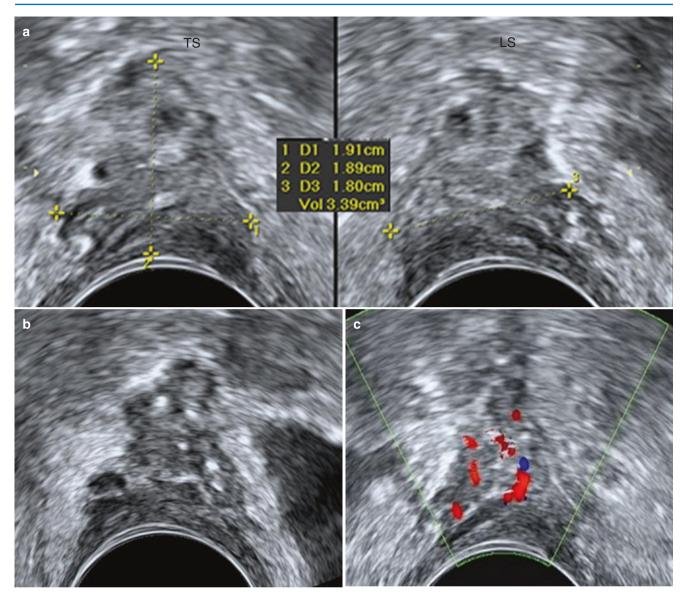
Vaginal vault metastasis. Patient had undergone panhysterectomy for an endometrial carcinoma the previous year. Clinical examination showed a polypoid growth in the vagina. (a) A solid heterogeneous mass was seen at the vaginal vault. (b) Irregular margins of the mass are seen. (c) The mass showed flow within on Doppler. *HPE*: metastatic endometrioid adenocarcinoma
